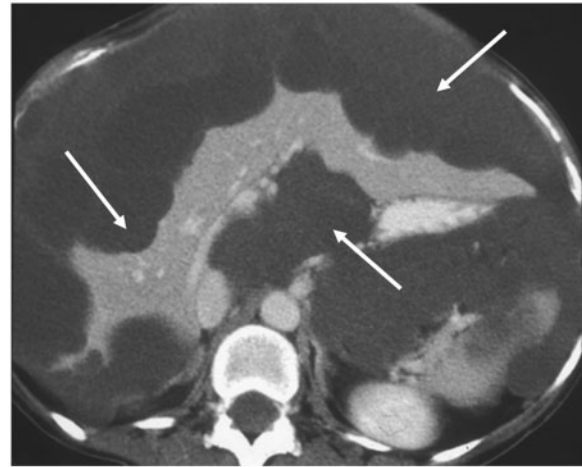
Pseudomyxoma peritonei. Axial contrast-enhanced CT shows the typical excessive scalloping of the liver and spleen from intraperitoneal mucin.
